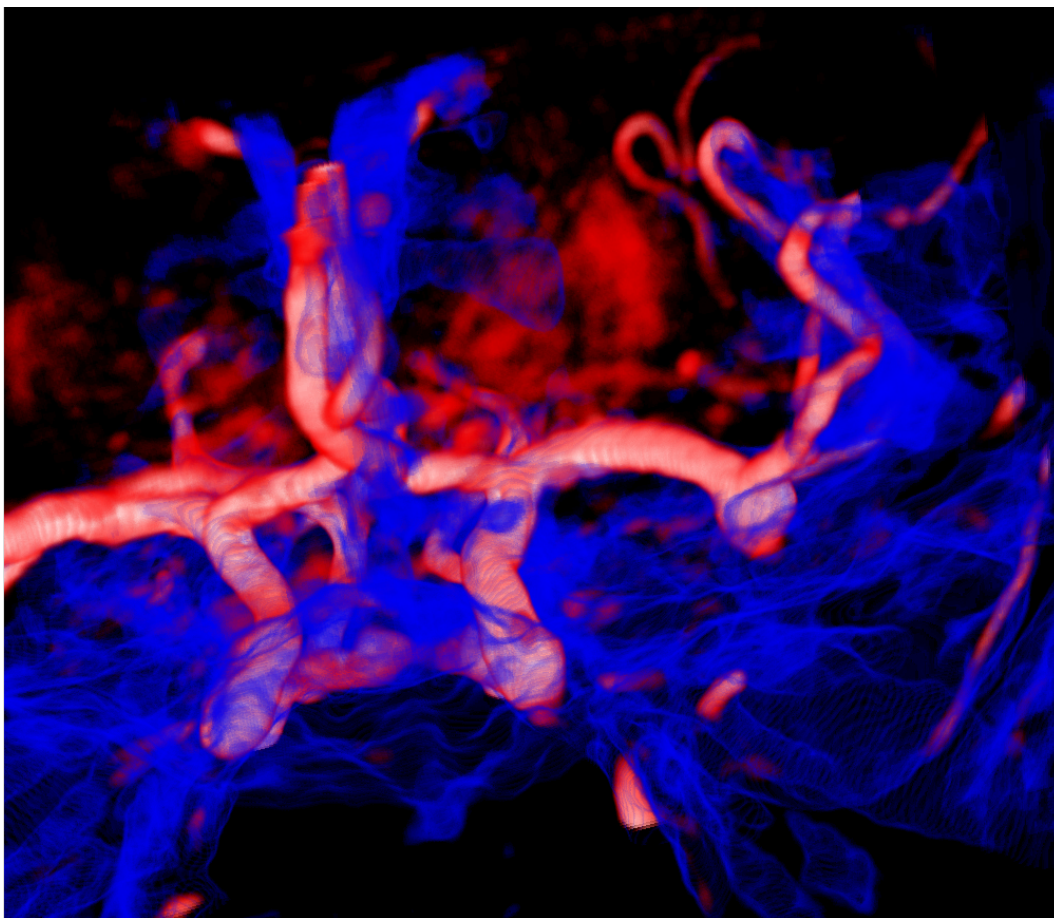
Dataset Aneurism 1. Volume renderings of MRI T1 (*blue*) and MRA (*red*).
